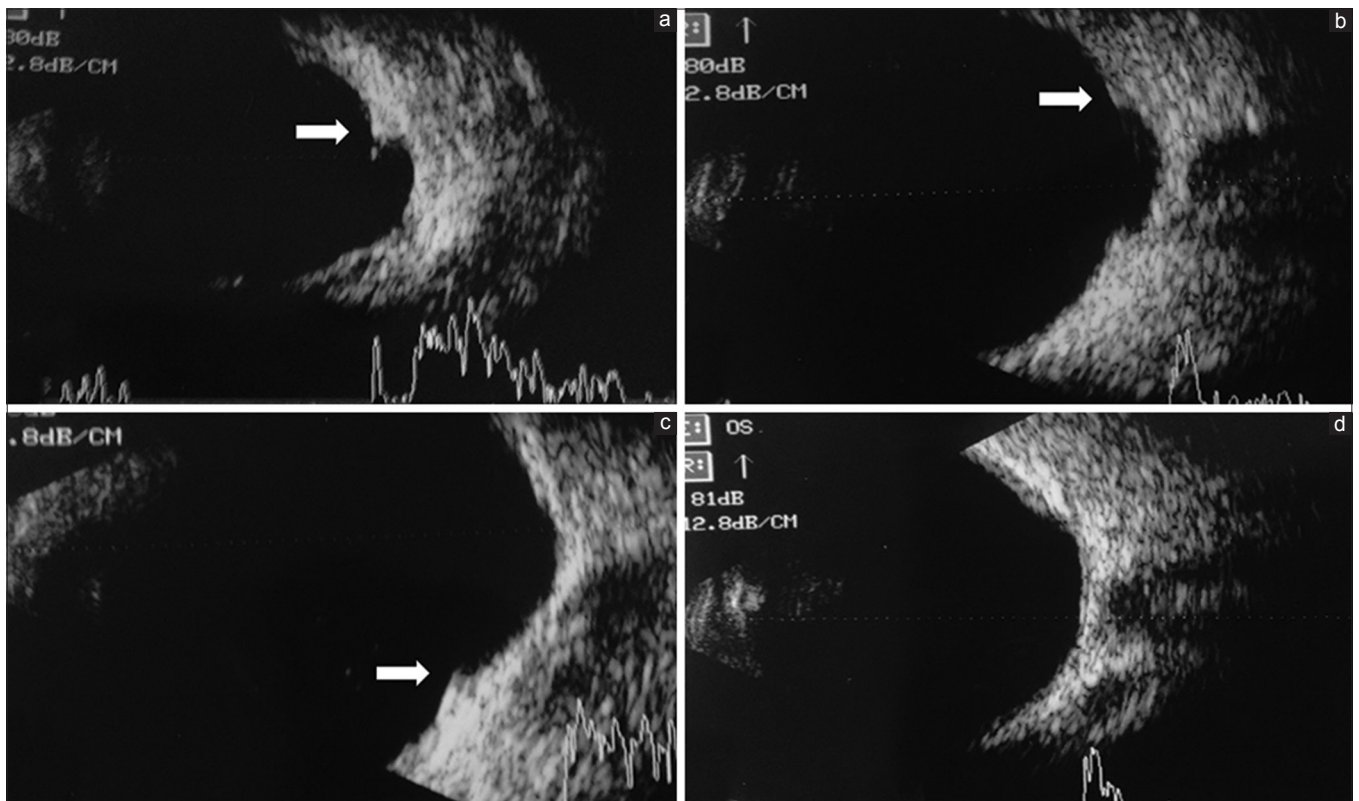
Ultrasound images of the posterior hump. (a-c) The posterior hump has been marked with white arrow at the edge of the choroidal excavation. (d) Large choroidal excavation can be seen without a posterior hump
